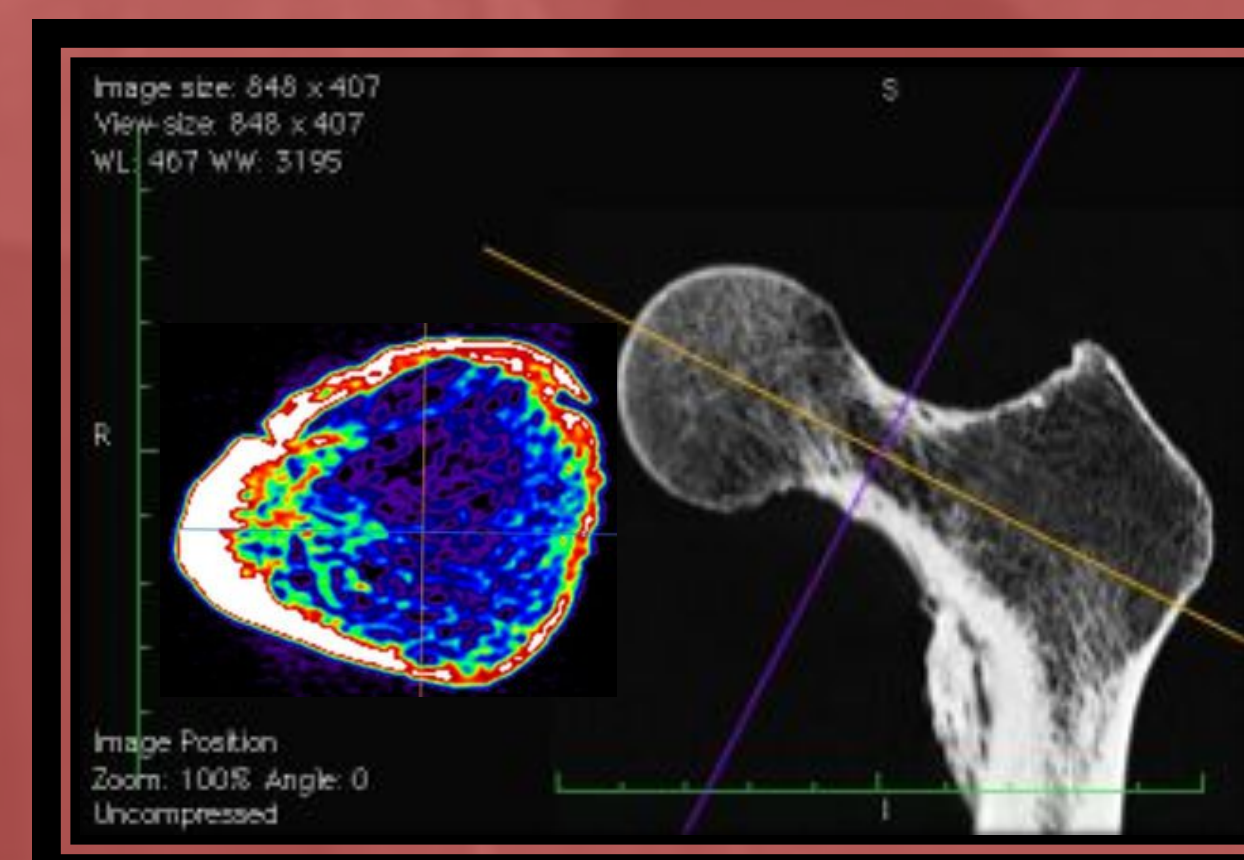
CT scan of a femoral neck with normal bone density. Note the lack of green relative to Fig. 5. The blue region is less dense than the green region. CT imagery by Dr. Bruno Frohlich.
